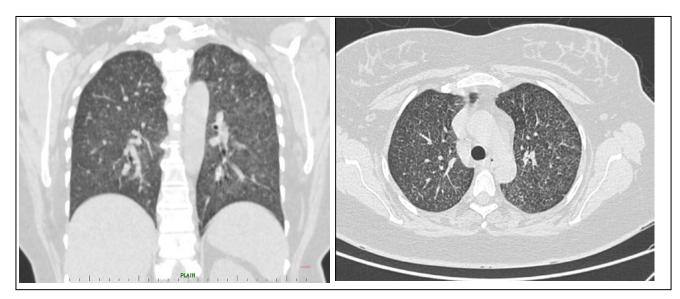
CT thorax showing miliary nodules taken on the 20th post operative day
